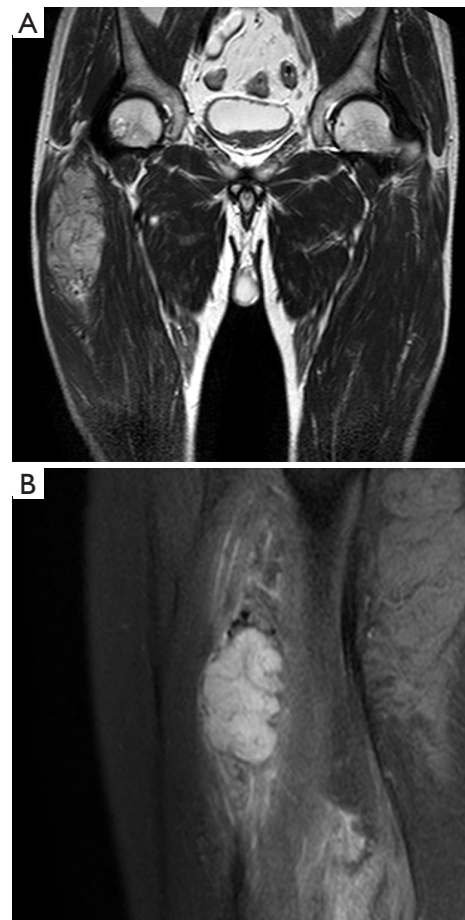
The tumors were performed on 3.0-T MRI scanner showed heterogenous high signal intensity compared with muscle on the coronal T2WI (A), and on the fat-suppressed sagittal T2WI (B). MRI, magnetic resonance imaging; T2WI, T2-weighted imaging.
